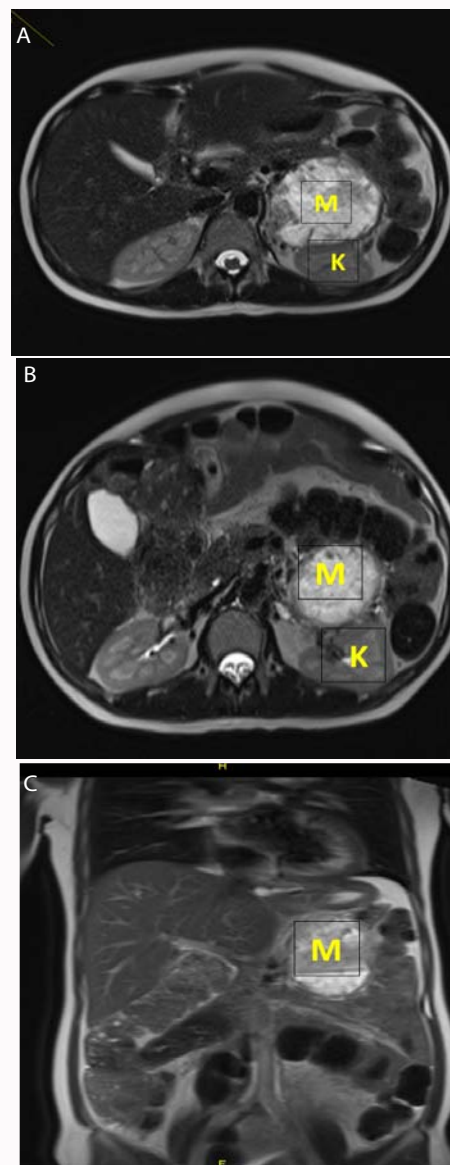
Magnetic Resonance Image [MRI] of the abdomen (axial and coronal planes) showing around heterogenous mass T2 hyperintensity measured 8.7 cm × 7 cm (M), the posterior part of it located near the left Kidney (K).
